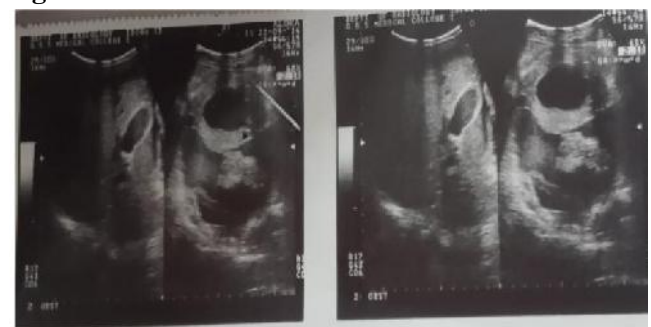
Ultrasound at 31 wks
